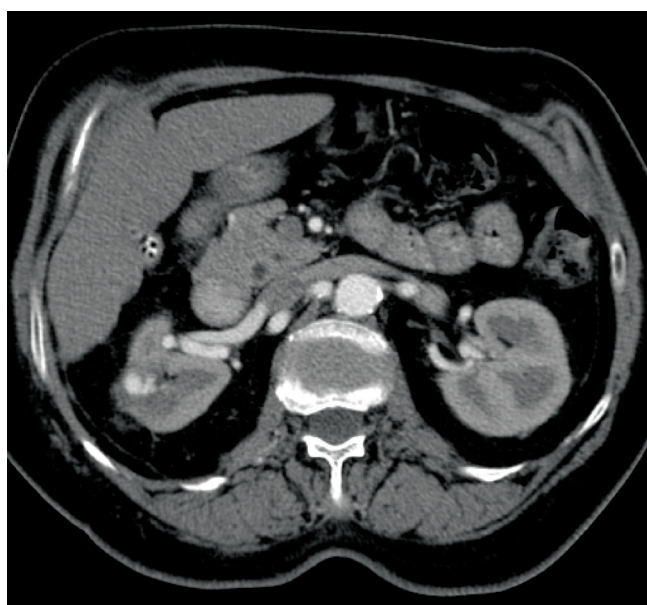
CT of arteriovenous fistula and pseudoaneurysm
